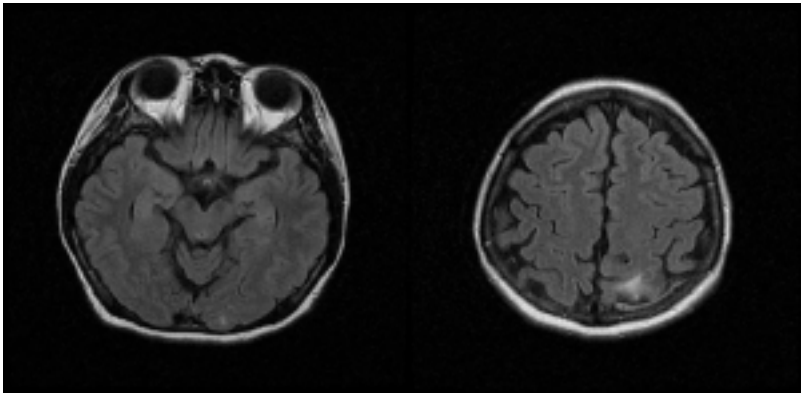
Brain MRI scan of Patient 1 three weeks after cessation of cyclosporine. T2 FLAIR imaging shows near-complete resolution of high signal intensities compared with Figure 1A.
